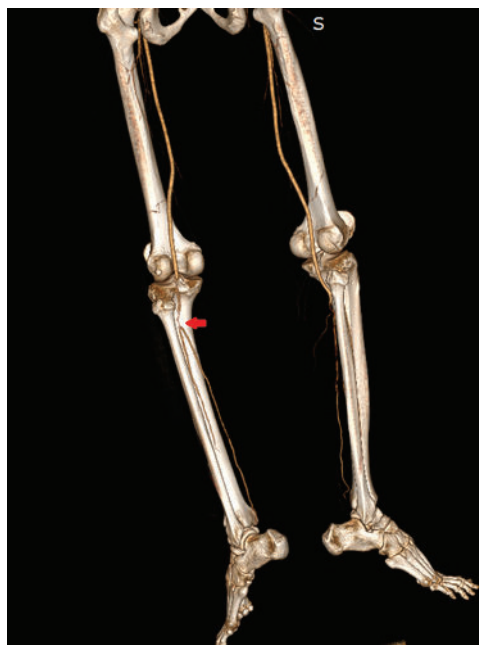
Computed tomography angiography of the lower limb of case number 2 reveals that the left proximal anterior tibial artery is partially occluded (red arrow).
